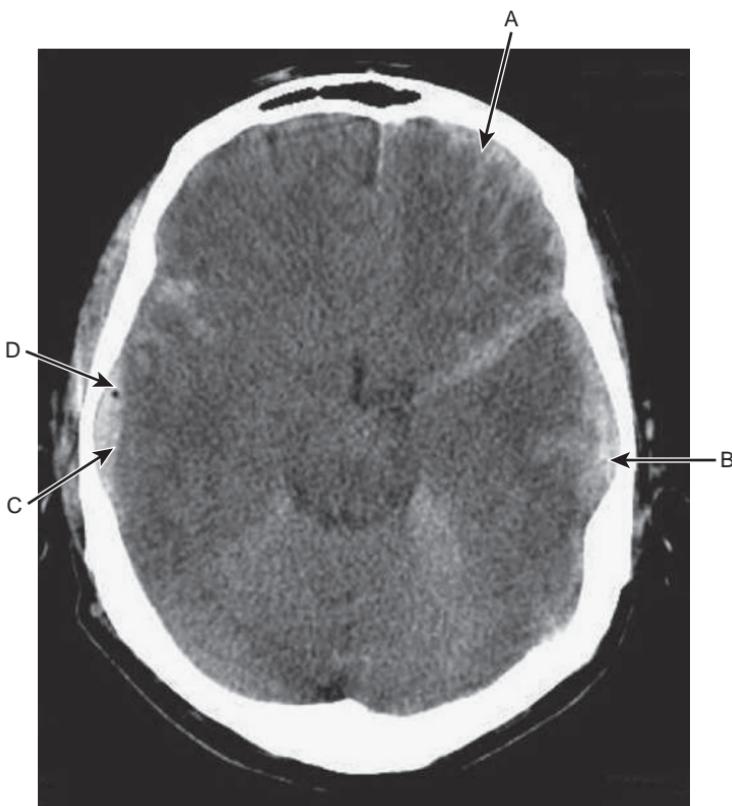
CT scan of the head showing subarachnoid hemorrhage (A), subdural hemorrhage (B), and subdural hemorrhage (C) with intracranial free air (D, black dot).
